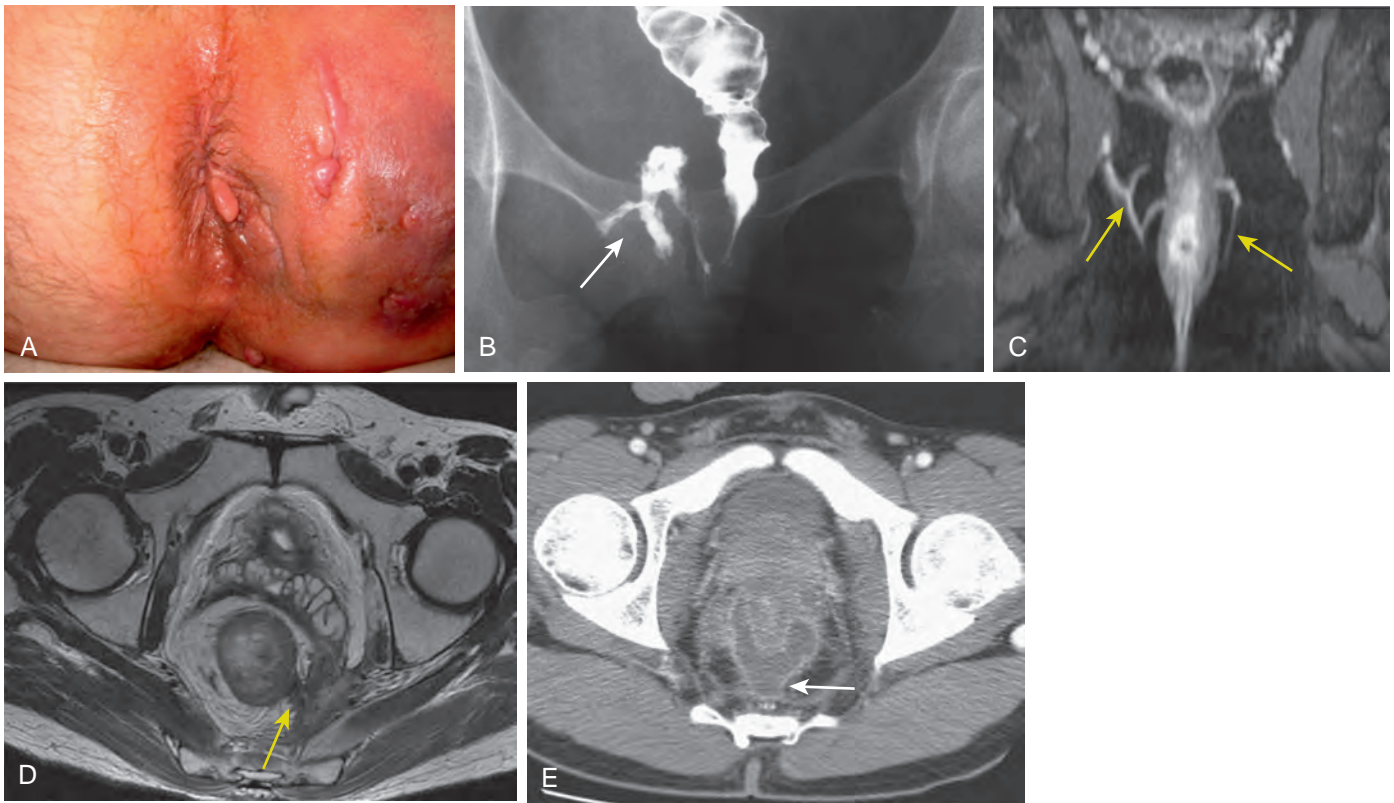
Crohn's disease: anorectal pathology. A. Multiple cutaneous fistulas are seen in the perianal region. B. Barium enema study shows a sinus tract (arrow) into the right perianal soft tissues. C. Coronal, fat-suppressed T2-weighted MRI scan of the anorectum shows multiple high signal intensity fistulas (arrows) into the perianal and mesorectal fat. D. Axial MRI scan shows mural thickening of the rectum, with a fistula (arrow) extending into the left piriformis muscle. E. CT scan shows a U-shaped abscess along the posterior aspect of the anorectal junction (arrow).
